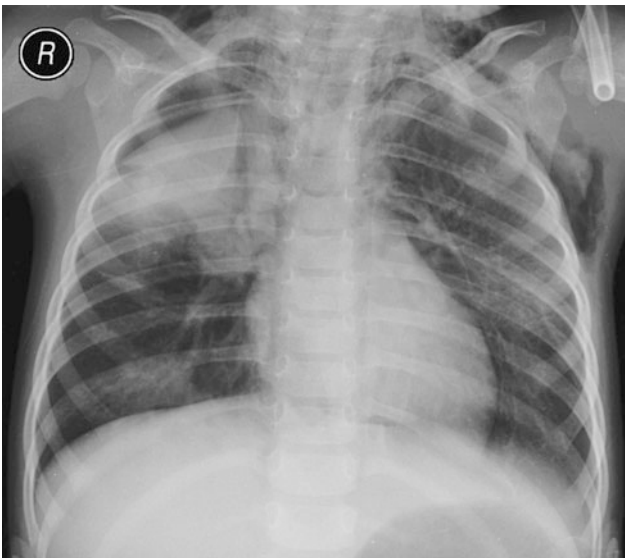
Frontal chest radiograph in a child with pneumomediastinum and right pneumothorax. Note streaks of air dissecting the upper mediastinal structures. The medial pleural line is also seen as well as subcutaneous emphysema
